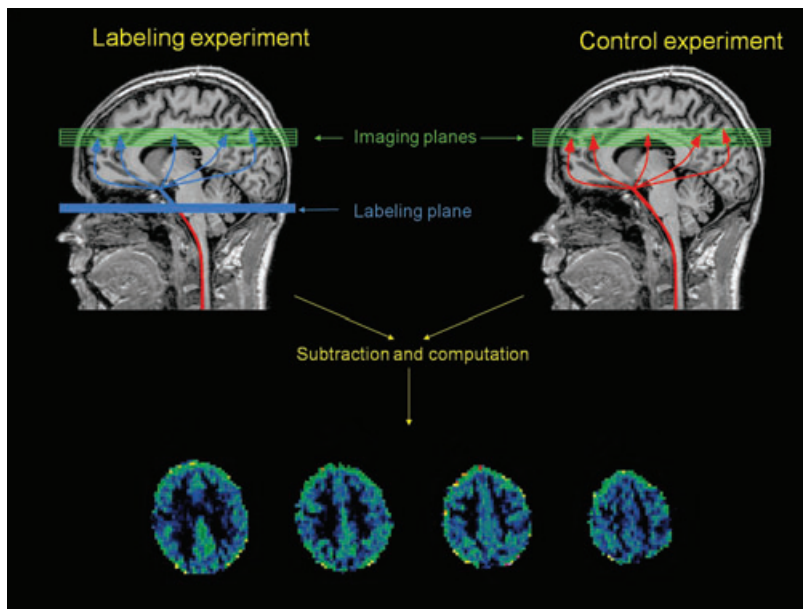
Basic principle of an ASL-MRI perfusion imaging experiment. Two image sets are acquired: One in which the blood water protons are magnetically labelled proximally to the imaging slices using a radiofrequency pulse and one unlabeled control image set. Subtraction of the image sets produce a map of the distribution of labelled protons which is used to compute quantitative CBF maps. *ASL images courtesy of Dr. K. Emblem, Rikshospitalet.*
